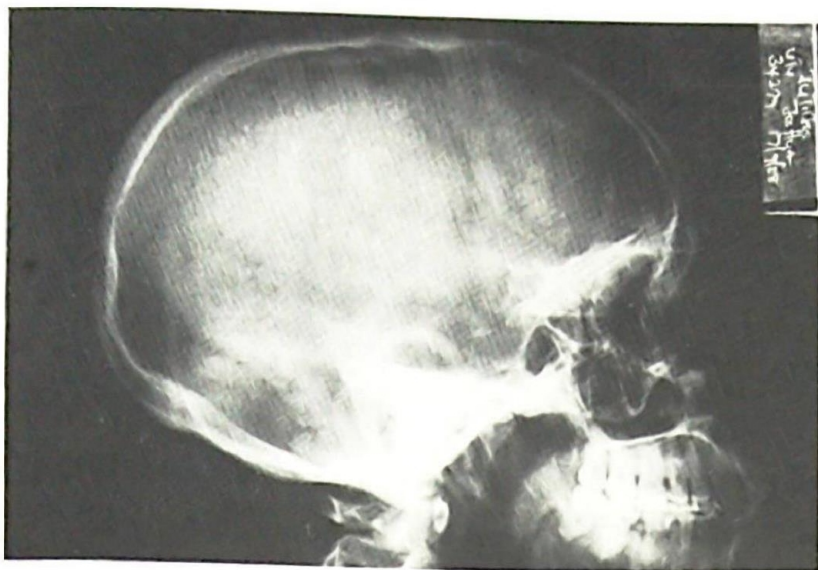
Radiograph of the skull, showing expanded sella with erosion of the clinoids.
